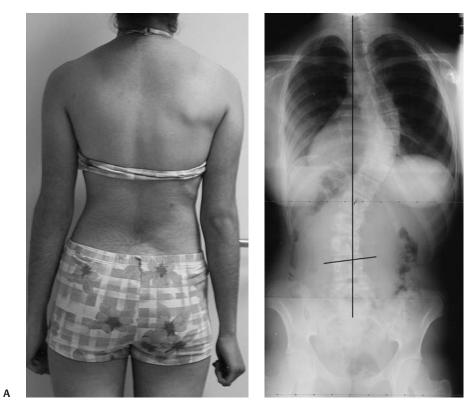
(A) Preoperative PA clinical photograph and (B) PA radiograph of a patient with a Lenke type 1B deformity, demonstrating a well-balanced standing posture with the head over the pelvis.
